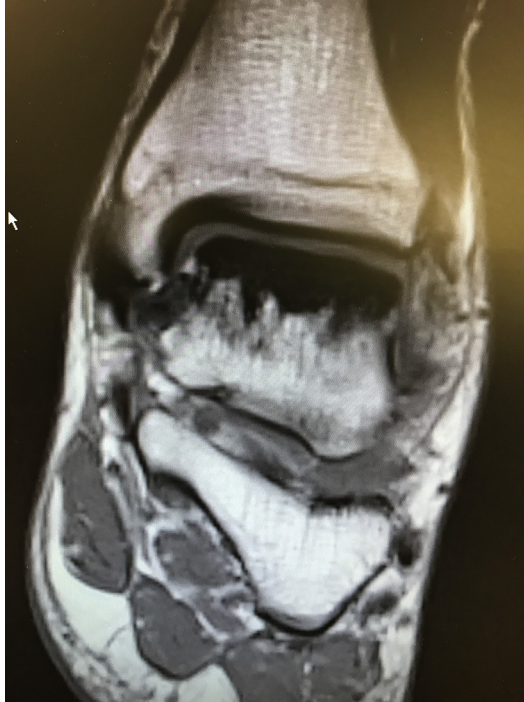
T1-weighted image showing superior talar body necrosis.
